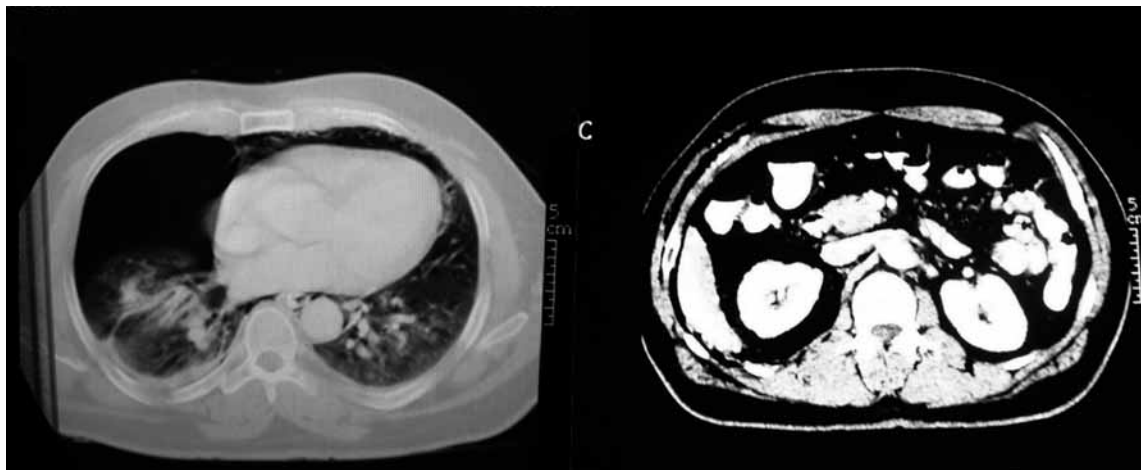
Computed tomography of the abdomen after ingestion of contrast material showed that there was no leakage of the contrast material to the retroperitoneum. Absence of free intra-peritoneal air excluded intra-peritoneal rupture of the duodenum. Right pneumothorax was verified.
